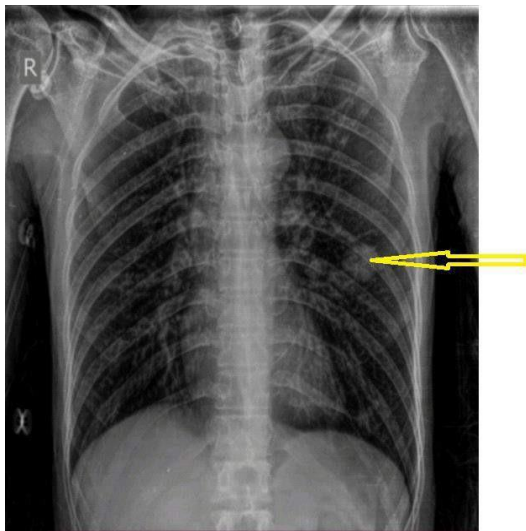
Well defined soft tissue opacity lesion with internal cavity in left mid zone on X-ray chest -PA view
